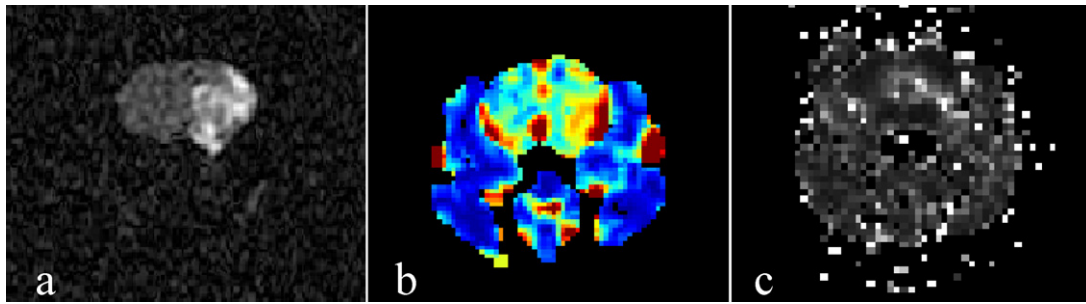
Example for peripherally hyperintense qT2'-lesion (c) in a hyperperfused area (b) within the DWI-lesion (a). Note that neither the whole DWI-lesion is hyperperfused nor the qT2'-lesion covers the DWI lesion entirely. DWI depicts brain tissue alone while in rCBF- and qT2'-maps the whole head appears.
